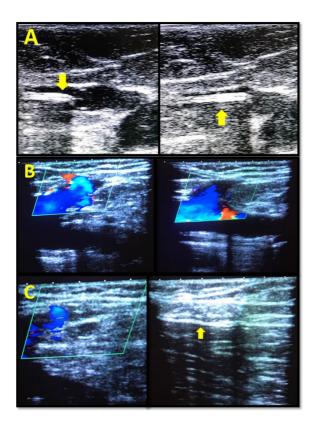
Ultrasound images of incompetent great saphenous vein (GSV) (A) VenaBlock Catheter at SFJ (B) After treatment with NBCA (C) Color Doppler of SFJ after treatment
